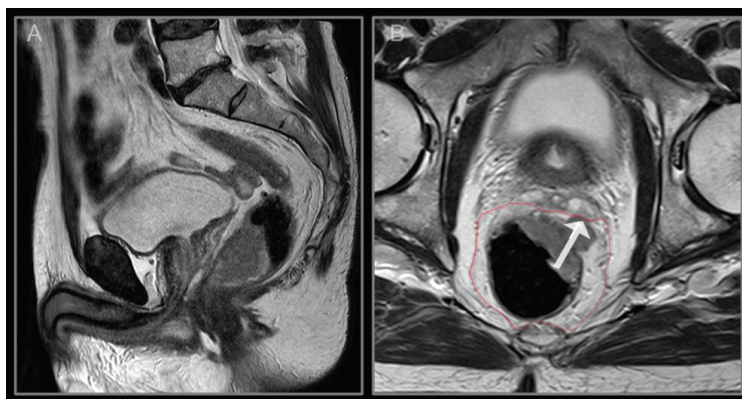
Sagittal (A) and transversal (B) magnetic resonance images of middle/low anterior T3 rectal cancer with tumor extension within 1 mm from the left seminal vesicle, indicated by arrow. The red line indicates the mesorectal fascia. Images provided by Knut Håkon Hole, Oslo University Hospital, printed with permission.
